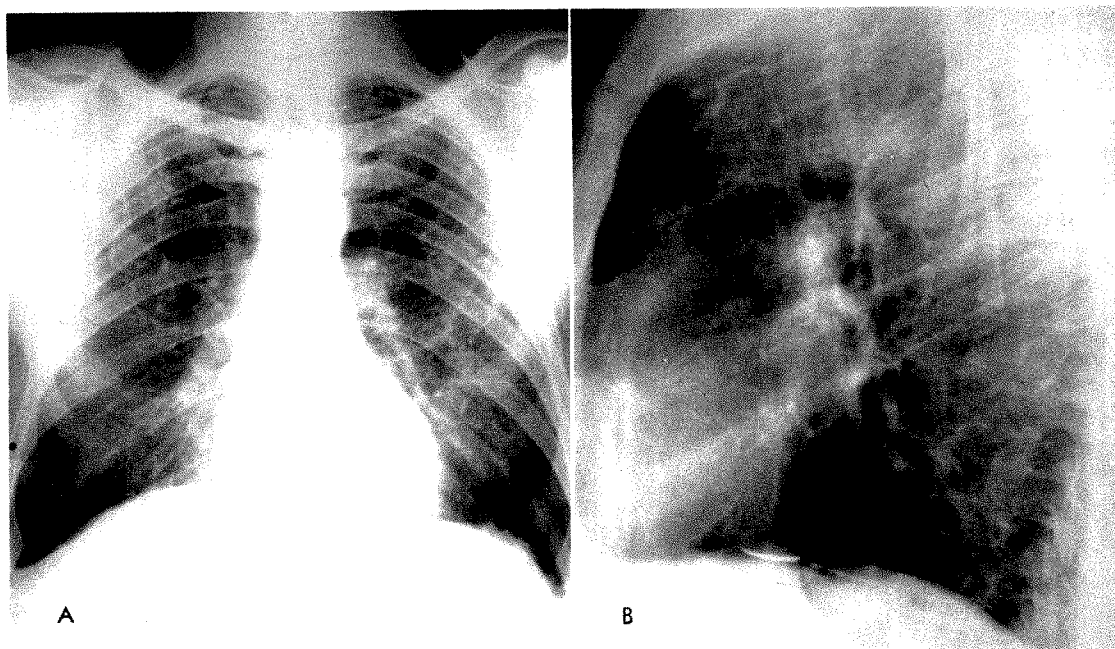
(*A*) Extensive pleural plaque formation over both lung fields. Right paramediastinal and bilateral diaphragmatic plaques are also seen. (*B*) Lateral roentgenogram shows the plaques disposed along the anterior aspect of the chest and adjacent to the diaphragmatic surface.
